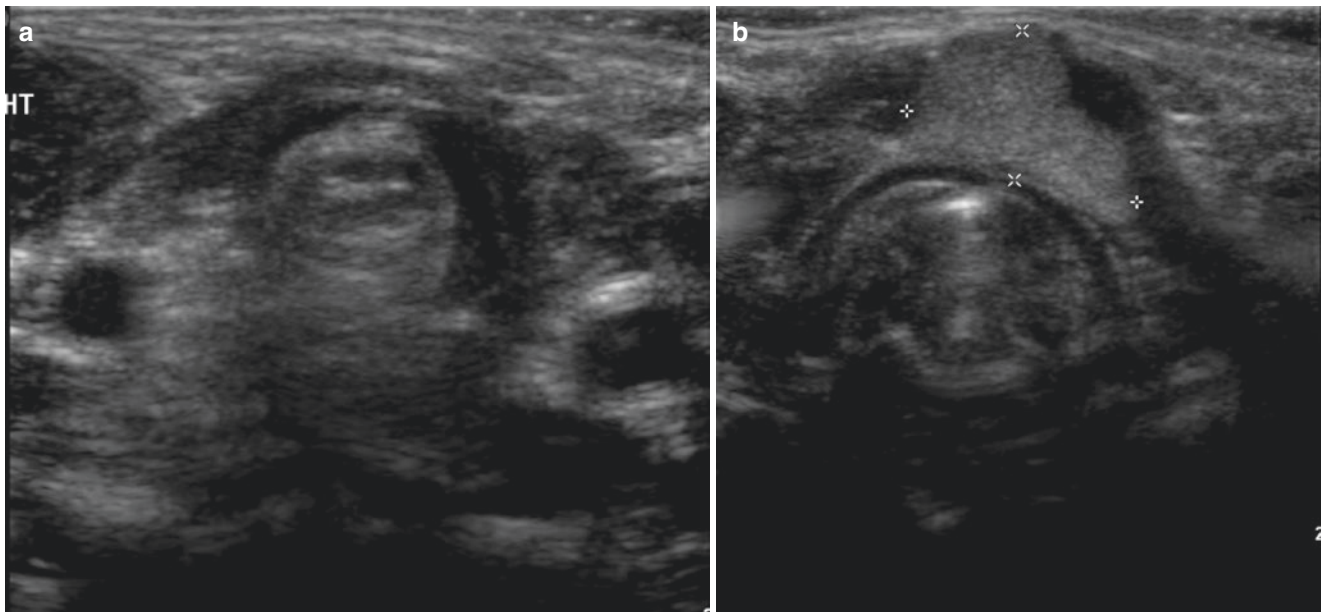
Ectopic thyroid gland in a neonate. (a) Transverse ultrasound image shows absence of thyroid tissue in its expected position in the lower neck. (b) Transverse ultrasound image of the upper neck
